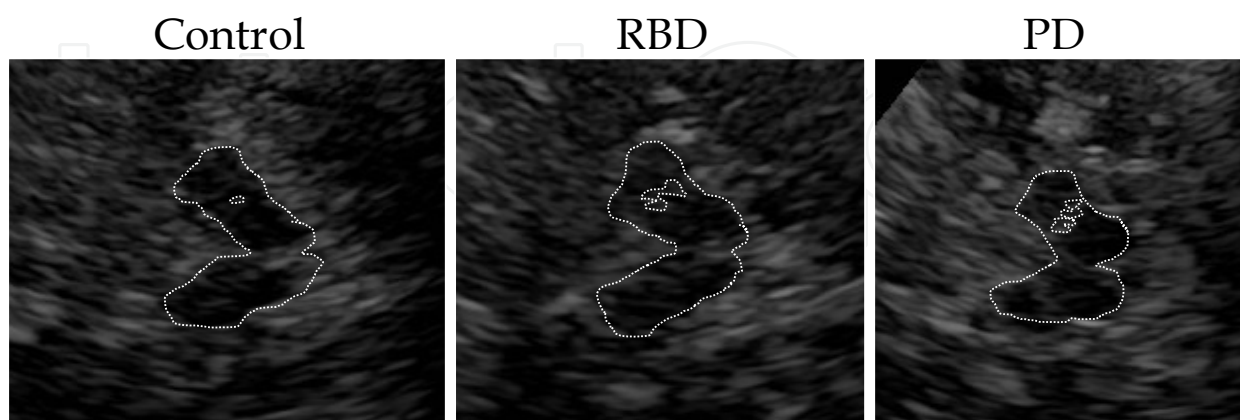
Typical examples of transcranial ultrasound images of the midbrain encircled by dotted lines in control, iRBD and PD patients. The area of enlarged hyperechogenic substantia nigra signal was encircled on the ipsilateral side for planimetric measurement.
